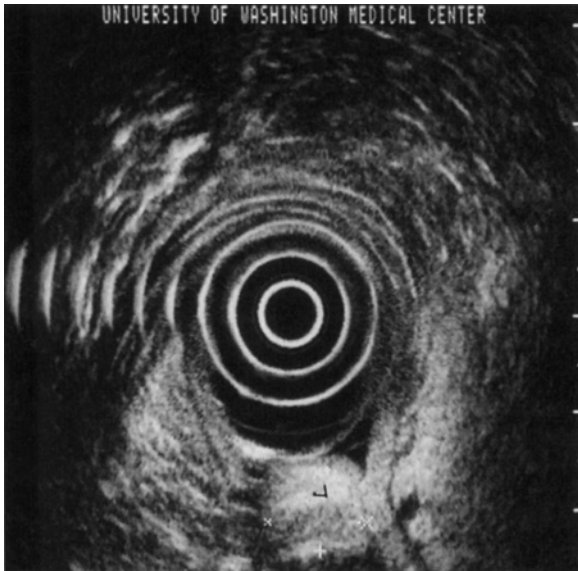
A duodenal lipoma (L) strongly attenuates the 12.5MHz ultrasound beam producing an acoustic shadow (arrows) in the tissue deep to the lipoma.
